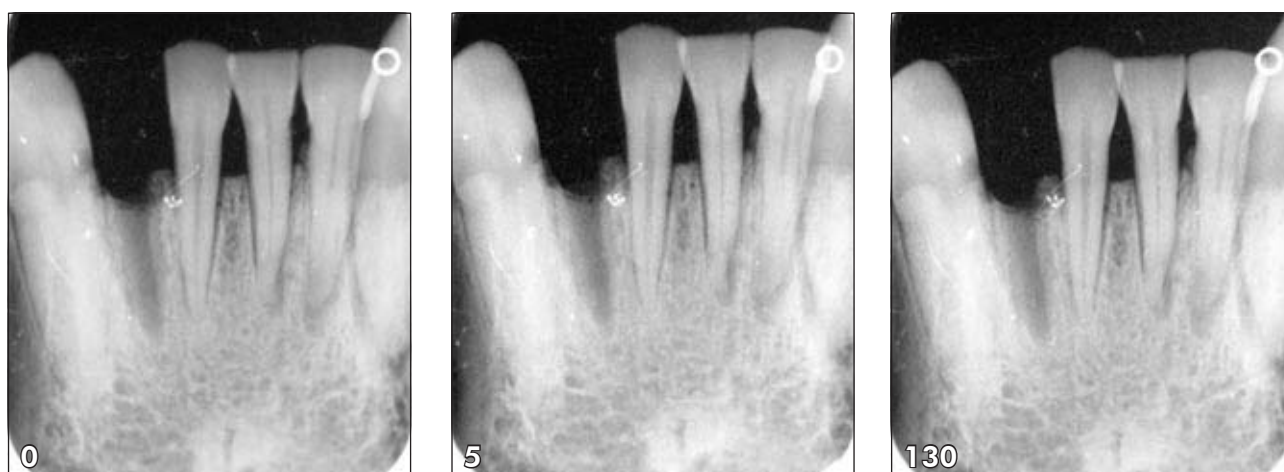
Radiographic images acquired with the DenOptix™ storage phosphor plates. 0, not erased. 5, erasing time set at five seconds. 130, erasing time set at 130 seconds.
